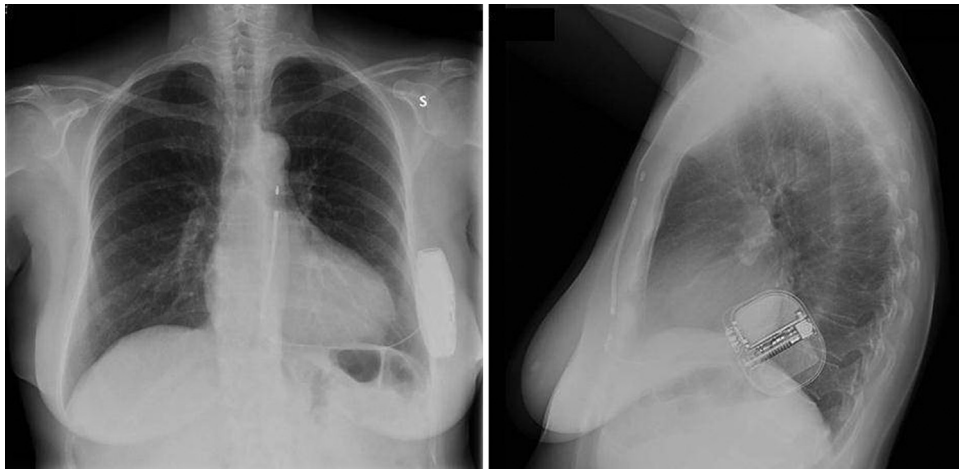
Postoperative chest radiography, anteroposterior view and lateral view, confirming the final position of the lead and S-ICD pulse generator.
